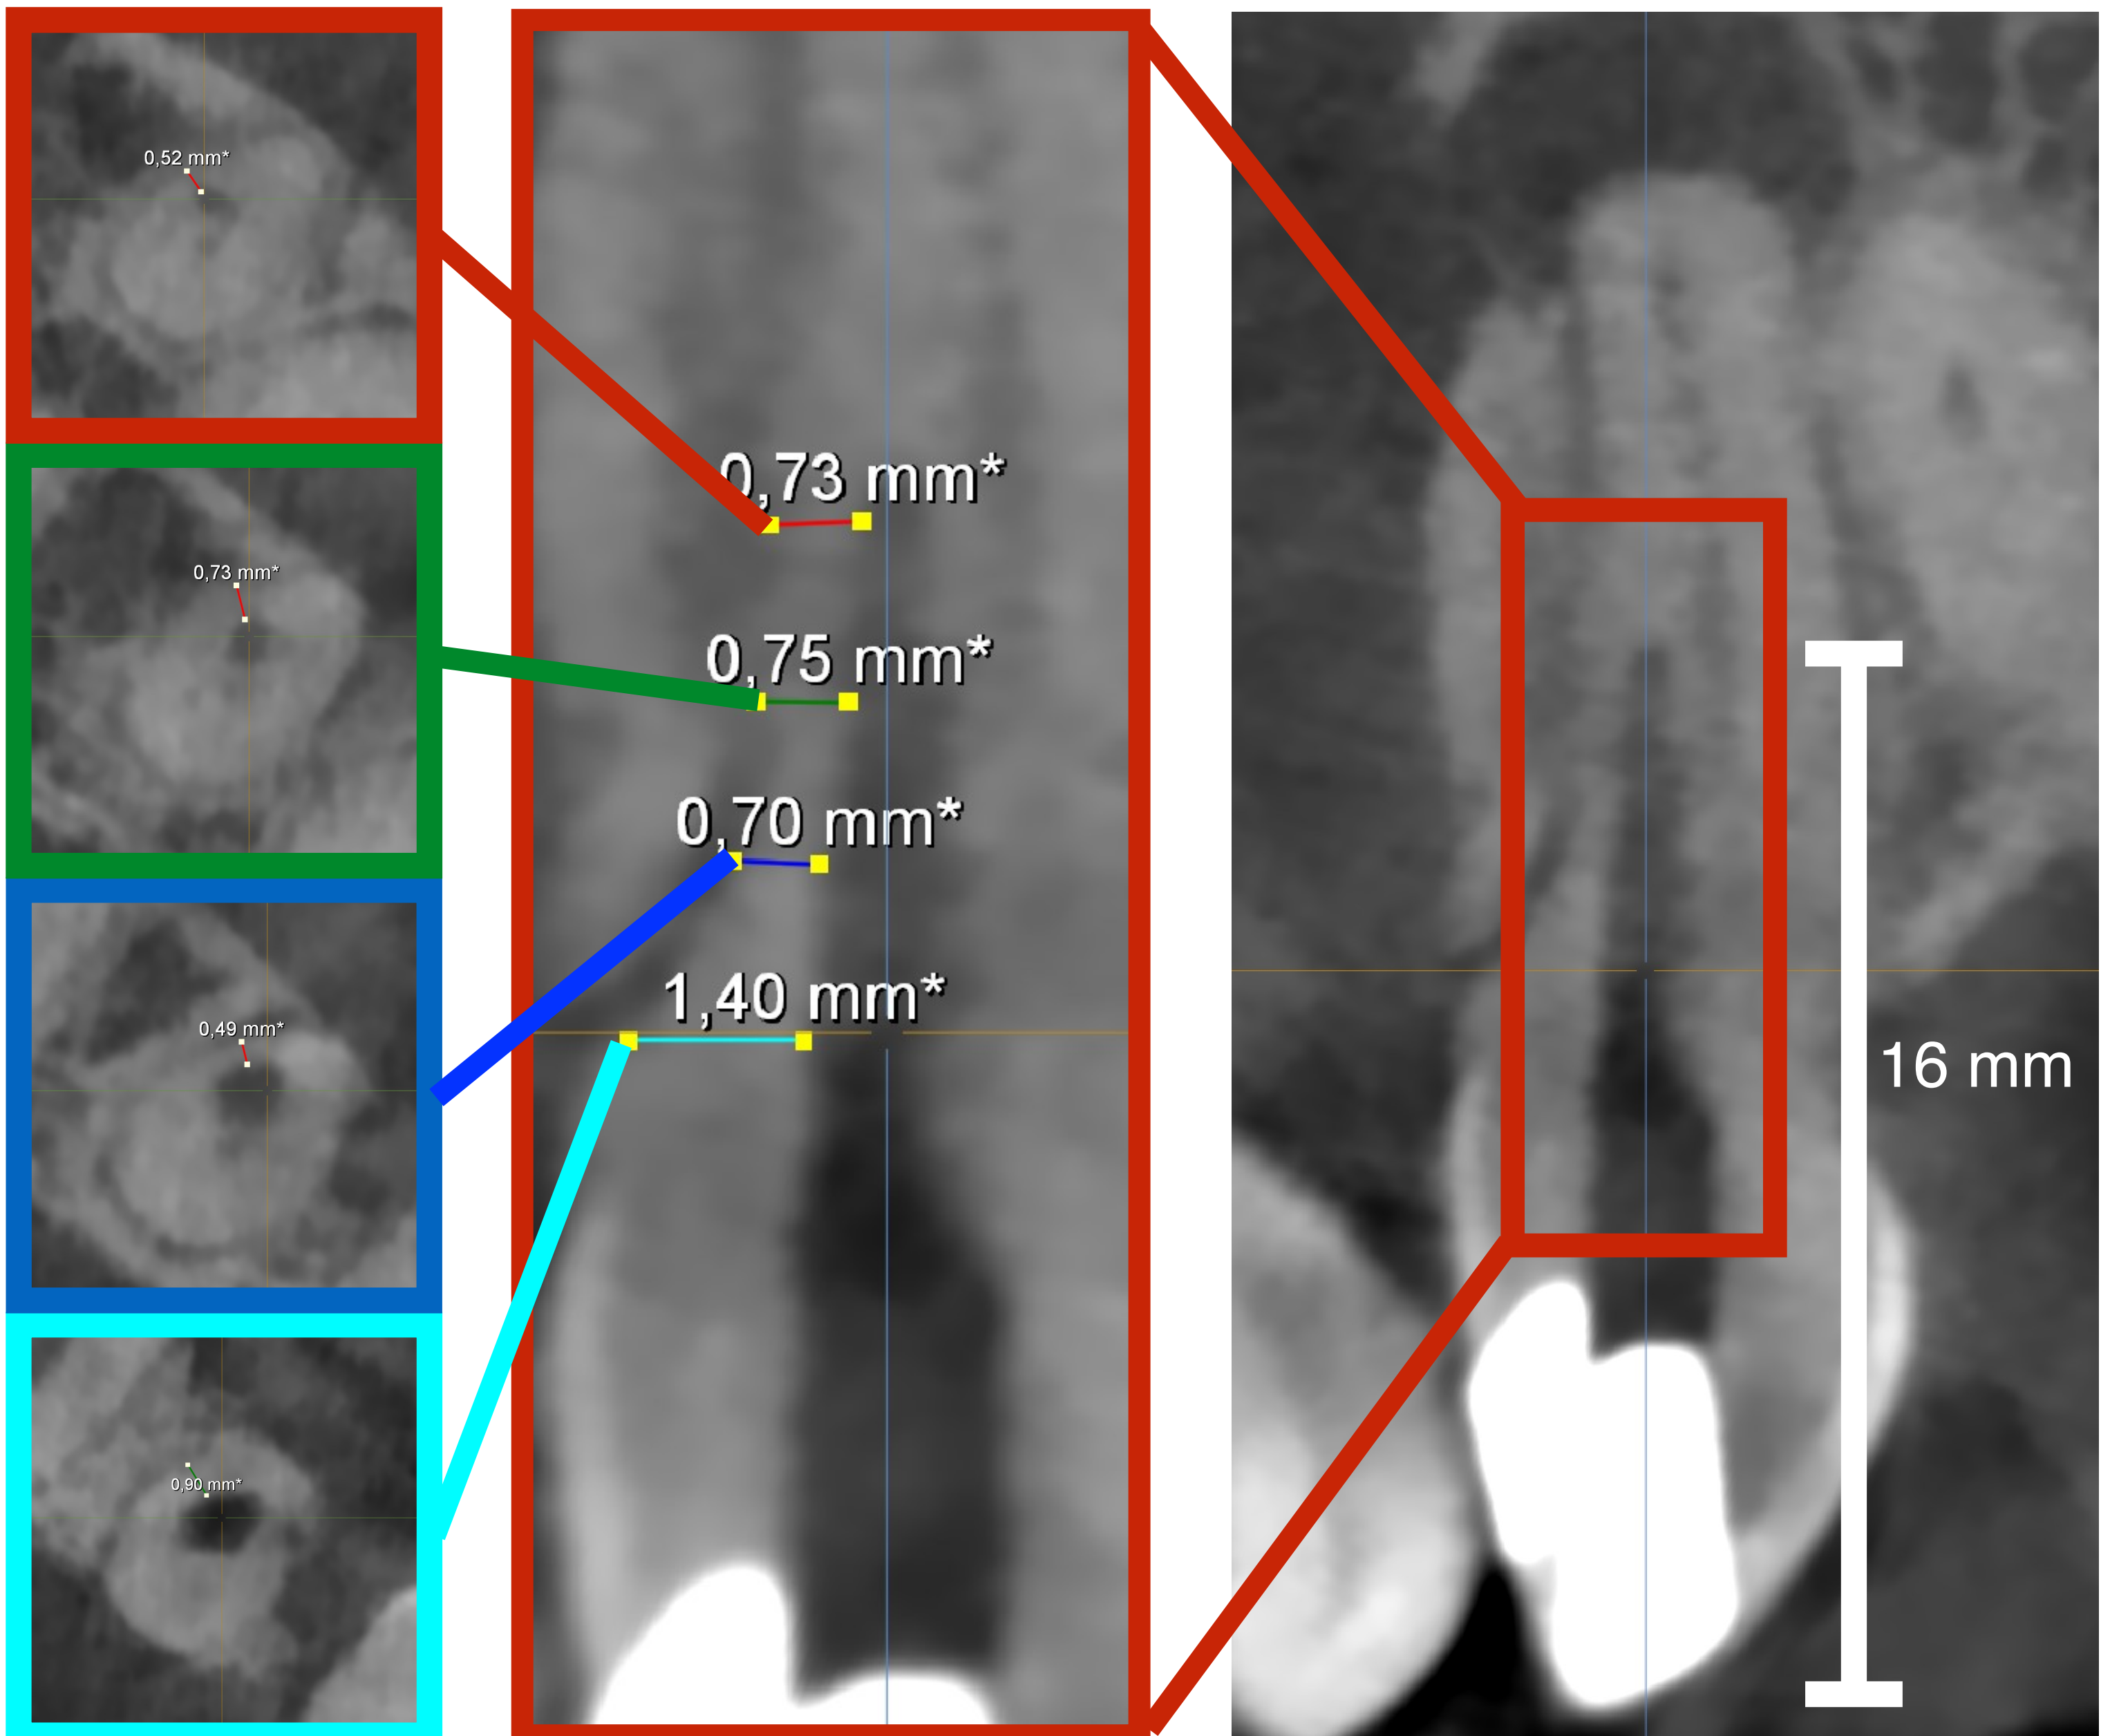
Control CBCT of access cavity (16 mm) before reaching the root canal lumen after additional preparation of 1 mm.
